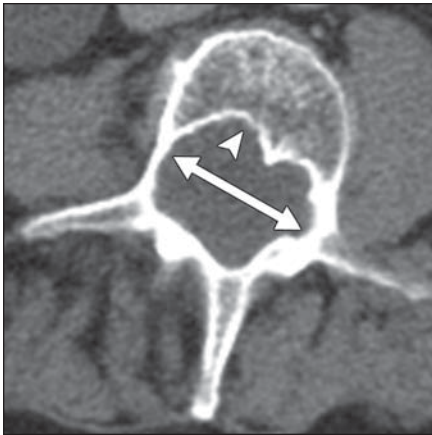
65-year-old man with neurofibromatosis type 1 and dystrophic spinal deformity. Transverse CT image of lumbar spine shows thinning of pedicles, widening of interpedicular distance (*double-headed arrow*), and posterior vertebral body scalloping (*arrowhead*). ←
